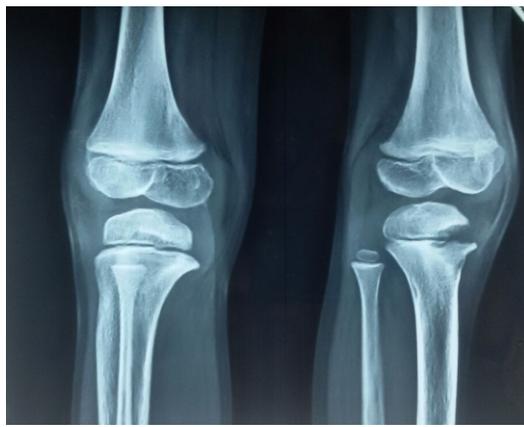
X-ray at presentation (pre - treatment)
